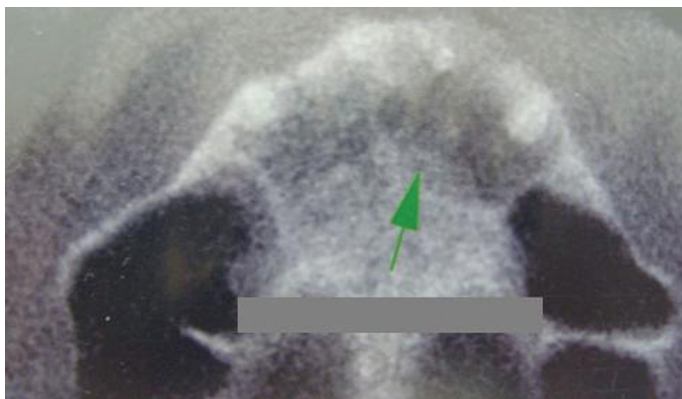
CT scan in axial view showing complete repair of the lesion (arrow).
